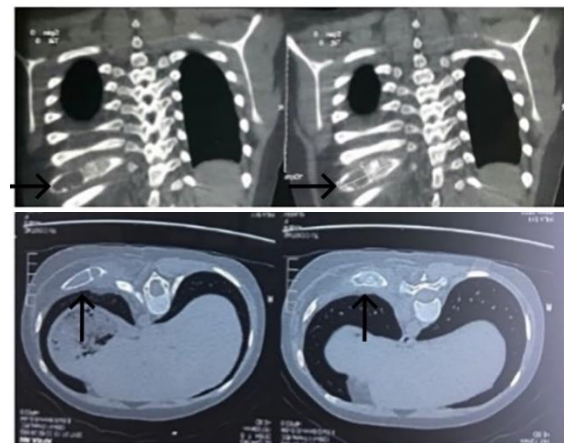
CT scan thorax showed a lytic lesion with soft tissue involvement.
